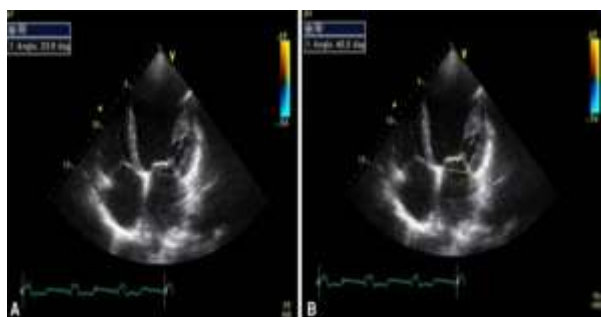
Anterior mitral leaflet angle (a) and posterior mitral leaflet angle (b) at mid-systole in apical four-chamber view
